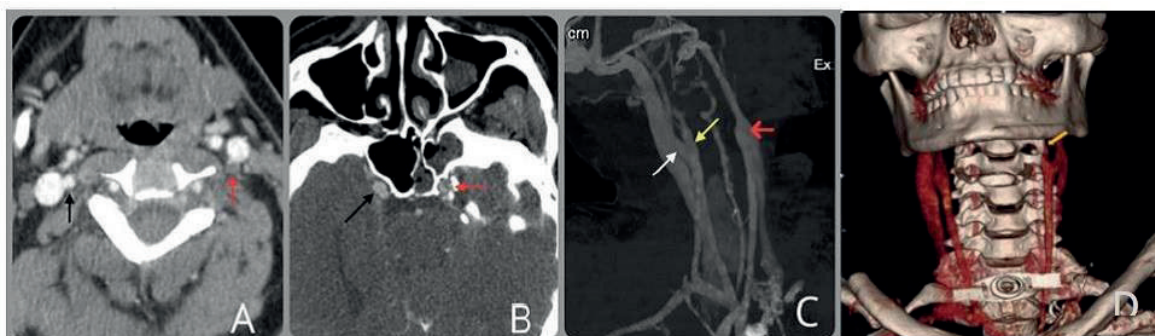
CT angiography reveals filling defect in cervical portion of the left internal carotid artery (LICA), indicated with red arrow (Image A). At the level of the carotid canal, an intimal flap on the left side is demonstrated (Image B, red arrow). On maximum intensity projection images (Image C and D), it is clearly appreciated that there is no luminal enhancement at neither left common carotid artery from the level of bifurcation nor LICA (red arrows). Only external carotid artery is filled with contrast media which are highly suggestive findings for dissection of LICA. 3D CT angiography reveals filling defect in cervical portion of the LICA, indicated with yellow arrow (Image D).
